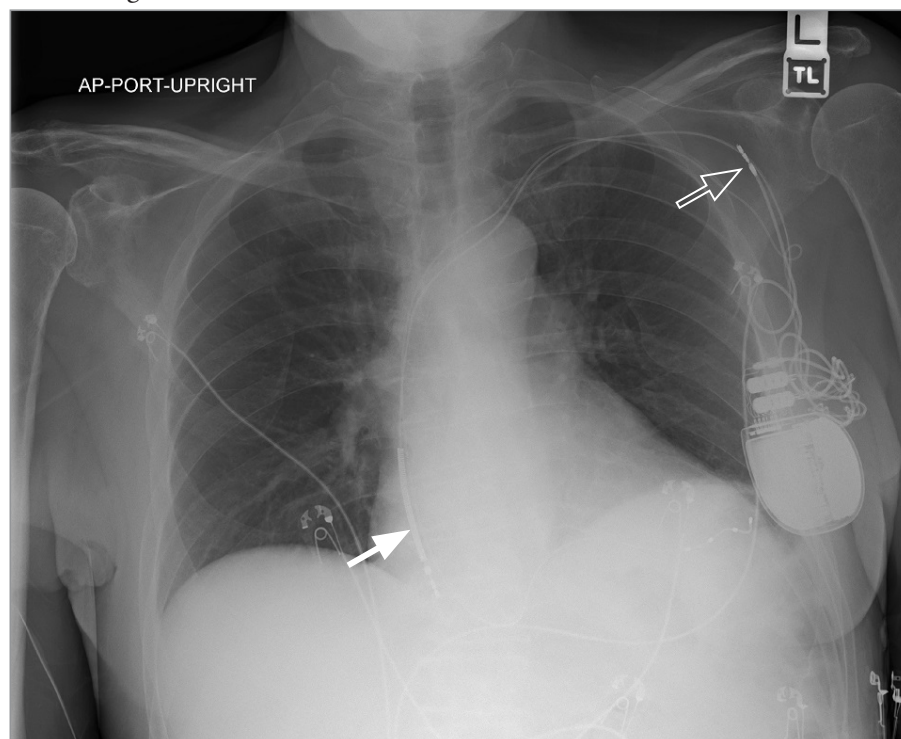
Chest x-ray obtained on presentation (solid arrow = right ventricular lead in the right atrium; open arrow = right atrial lead).
